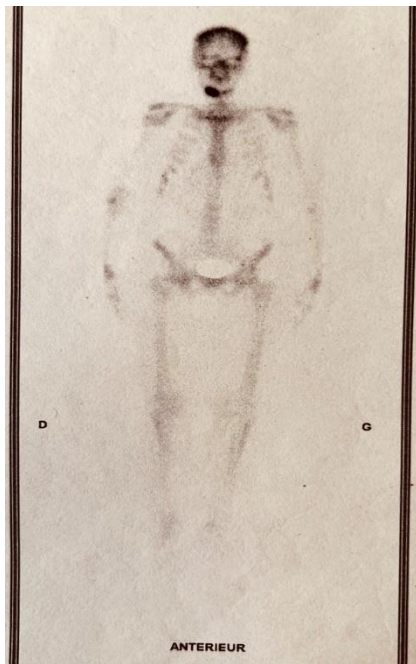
Bone scintigraphy showing increased radiotracer uptake in the right mandibular region without evidence of distant skeletal involvement
